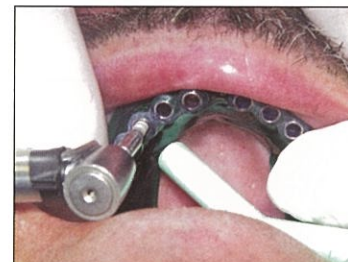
Placing mini dental implant through the CT guided stent with 20:1 handpiece.
